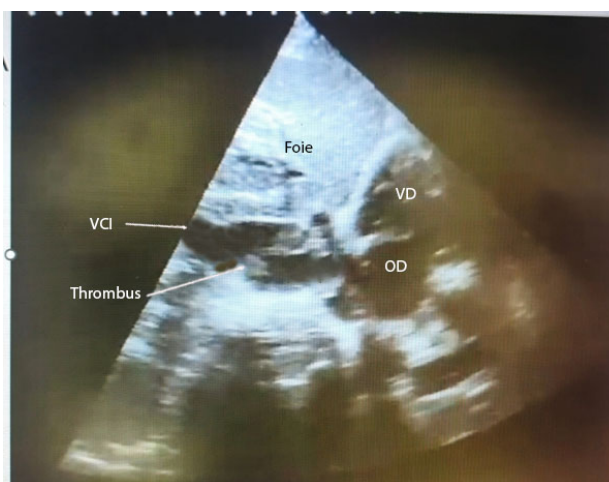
Two-dimensional transthoracic echocardiography, subcostal view. The inferior vena cava (VCI) is dilated (25 mm) and contains a voluminous hyperechoic thrombus (20 × 9 mm) extending to the juxtatrial segment. OD = right atrium; VD = right ventricle; VCI = inferior vena cava.
